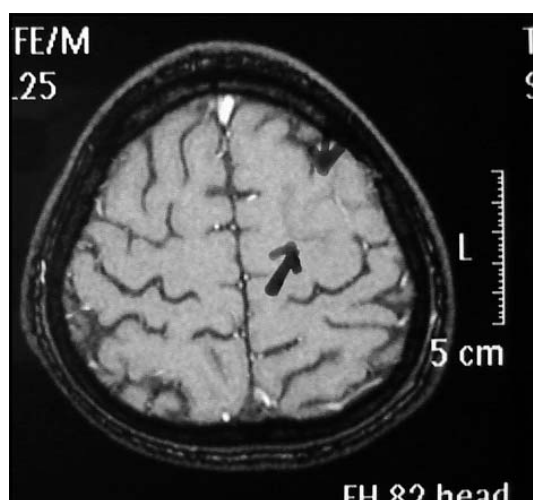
At vertex level of left posterior frontal region, cerebral MRI of multiple infarctions
